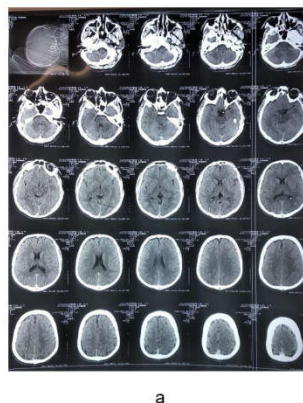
Figure iv (Patient 4): Hematoma size did not increase. Patient was treated conservatively. (a) CT head on admission (b) CT head on 4th post admission day.
